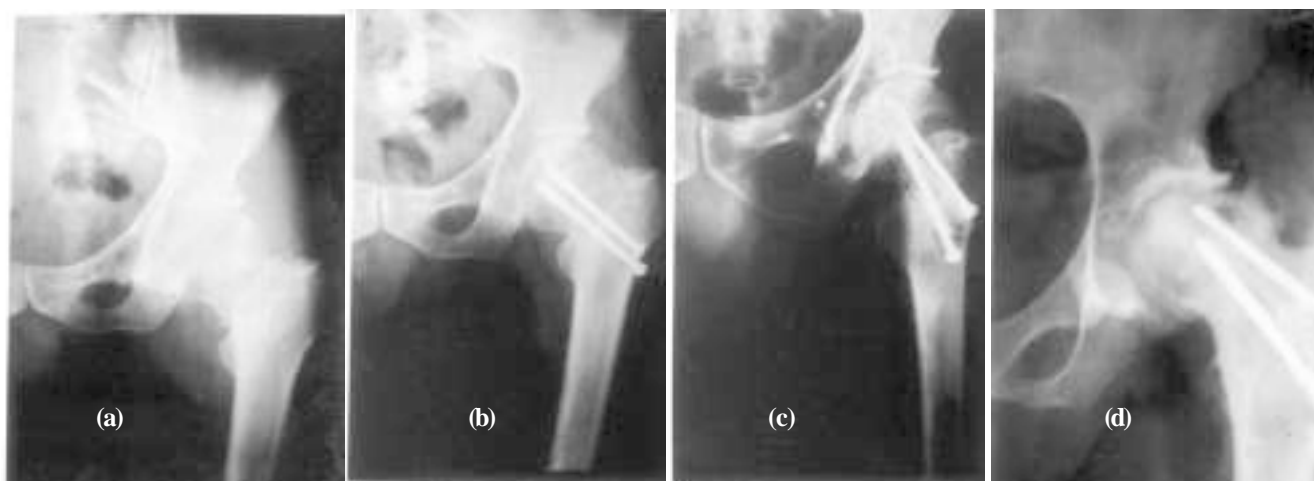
Radiograph showing (a) ununited femoral neck fracture, (b, c) follow up at 6 months showing union, (d) showing avascular necrosis and collapse at 2 years.
